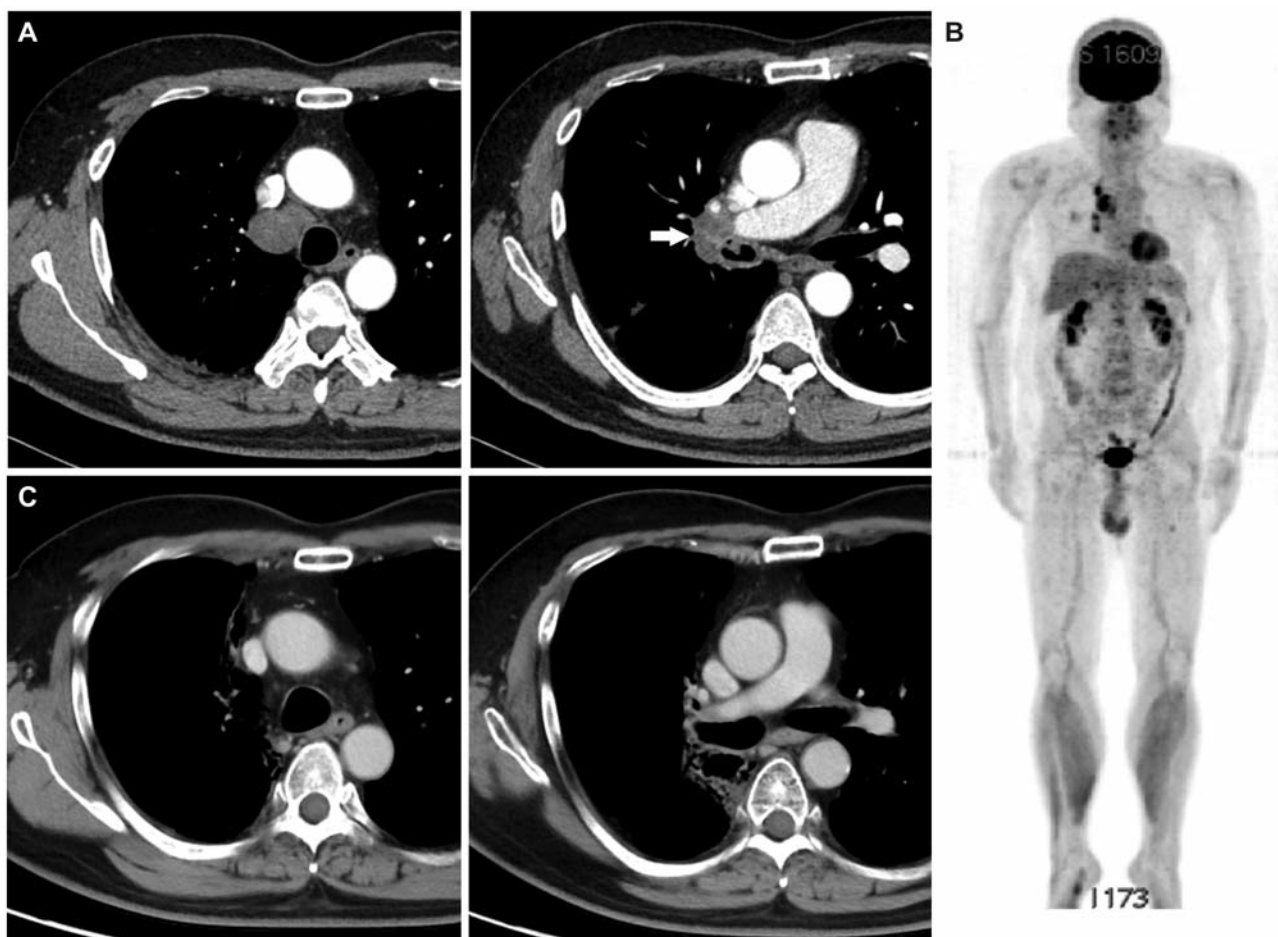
(A) Computed tomography (CT) scan of the thorax at initial presentation showing a tumor at the right second carina (arrow) and mediastinal adenopathy. (B) Positron emission tomography/CT scans showing fluorine-18-deoxyglucose accumulation in the tumour and mediastinal lymph nodes. (C) CT scan of the thorax after chemoradiotherapy showing marked tumor shrinkage.
